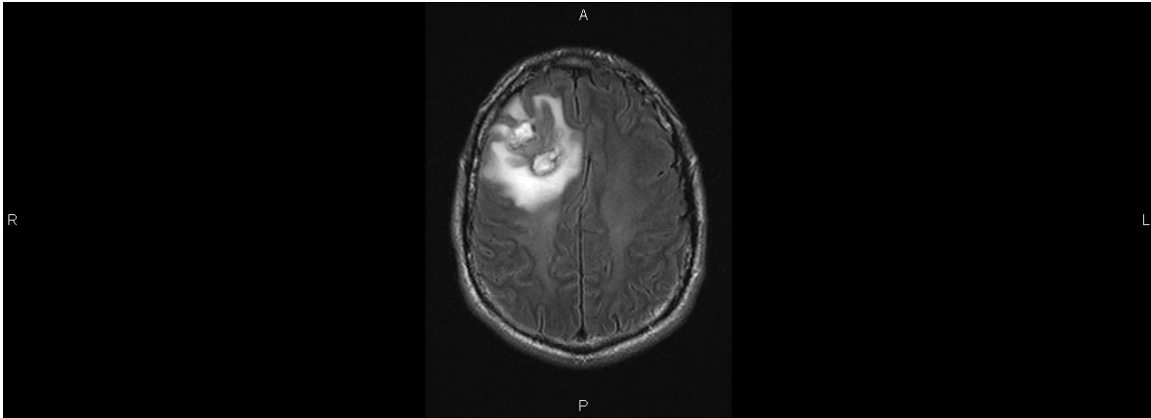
Axial FLAIR MRI. Frontal lobe lesion with non-homogeneous central areas and extensive peripheral high-signal intensity edema with mass effect.
